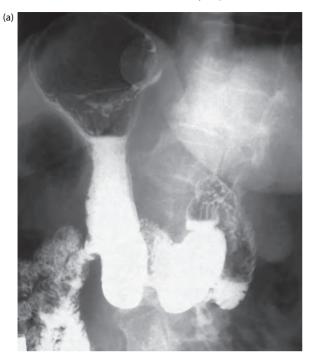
(a) Barium swallow showing a smooth ovoid tumour at the gastro-oesophageal junction. The lesion was a benign leiomyoma. (b) CT scan of the same patient.
